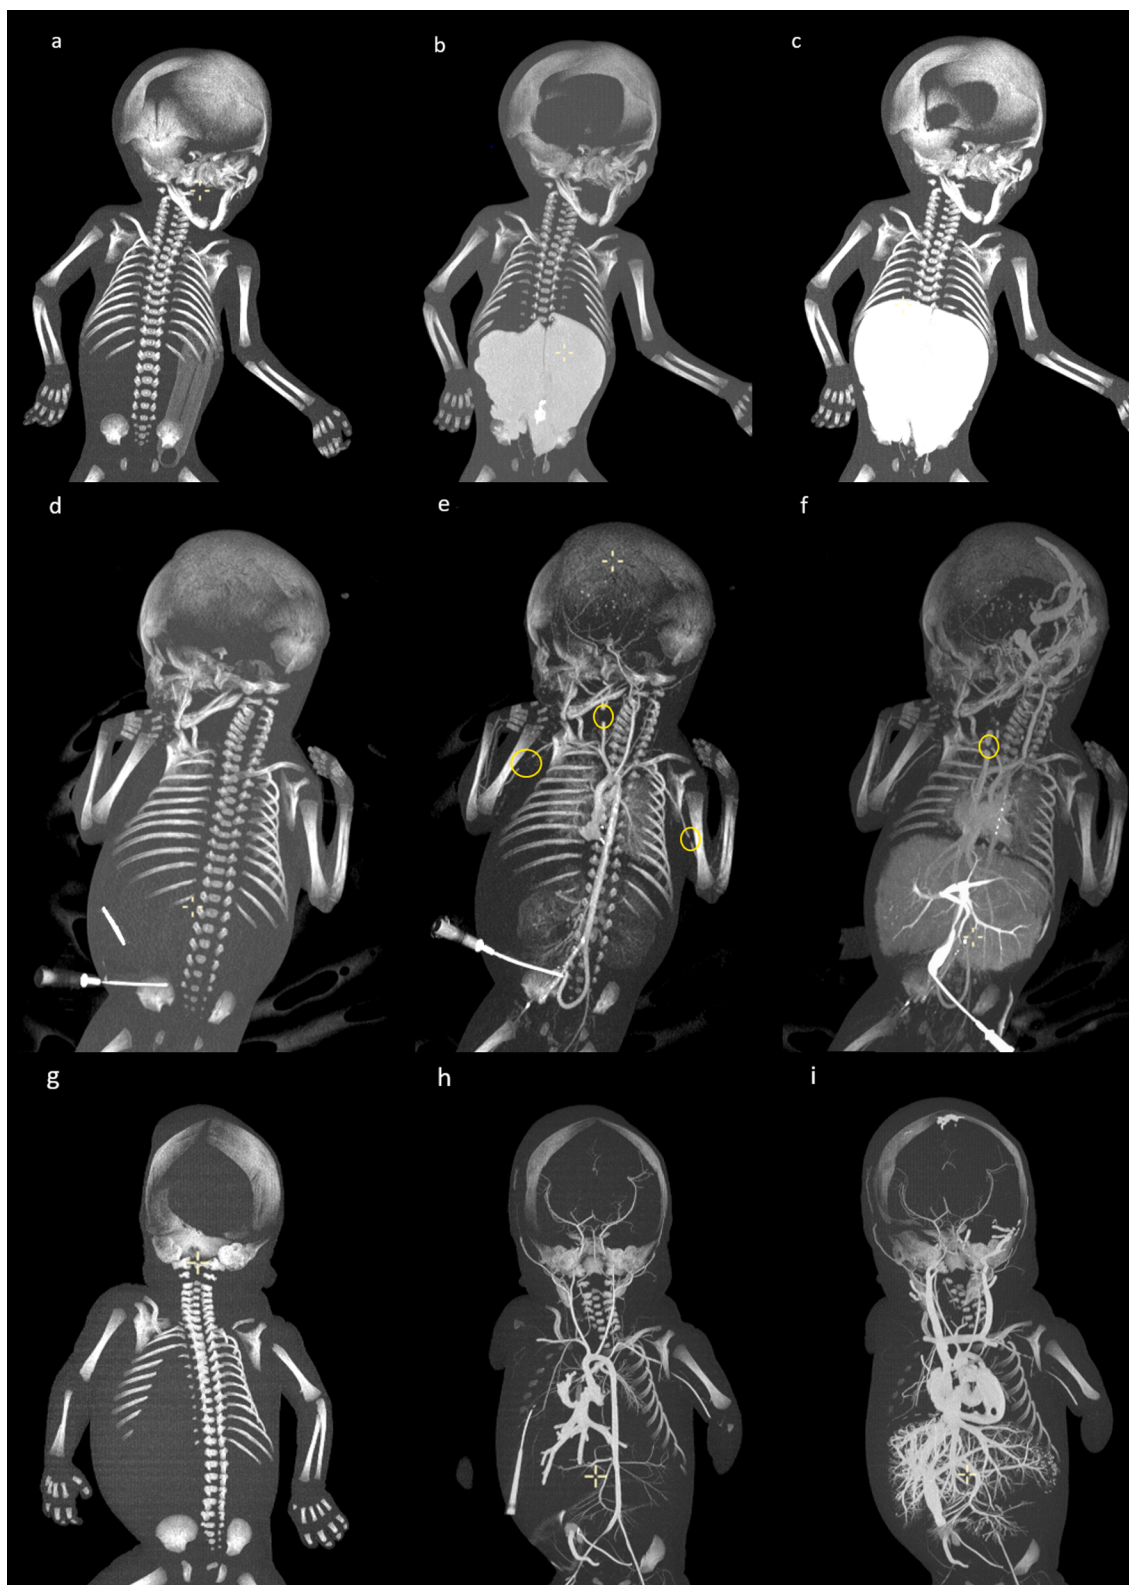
Fig. 2A (a-b-c) Fetus deceased at 154 days of gestational age. CT angiography image using MIP before injection (a), after arterial opacification (b) and after venous opacification (c) show no opacification, corresponding to a score 0 and artefactual abdominal extravastion. Fig. 2B (e-f-g) Fetus deceased 170 days of gestational age. CT angiography image using MIP before injection (d), after arterial opacification (e) and after venous opacification (f) show no opacification (score 0), partial opacification (score 1 – yellow circle) and complete opacification (score 2). The yellow circles surround the brachial arteries and the right carotid artery (e) as well as the right brachiocephalic trunk (f). Fig. 2C (g-h-i): Fetus deceased 196 days of gestational age. CT angiography image using MIP before injection (g), after arterial opacification (h) and after venous opacification (i) show complete opacification (score 2) of the Willis polygon and hepatic veins.
